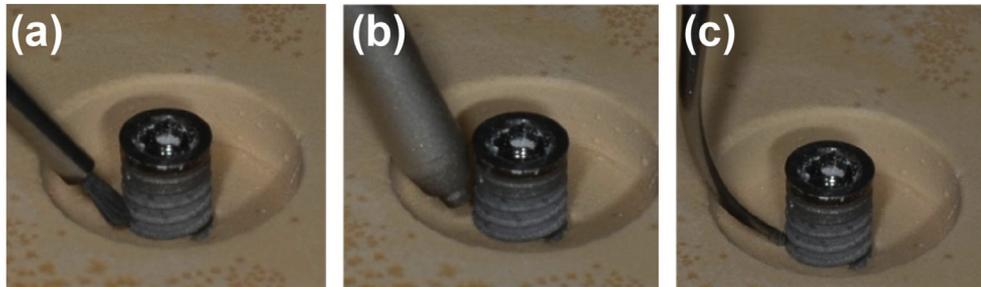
Different debridement groups. (a) Titanium brush (Ti); (b) β -tricalcium phosphate air abrasive (Air); (c) Titanium ultrasonic scaler tip (US).
